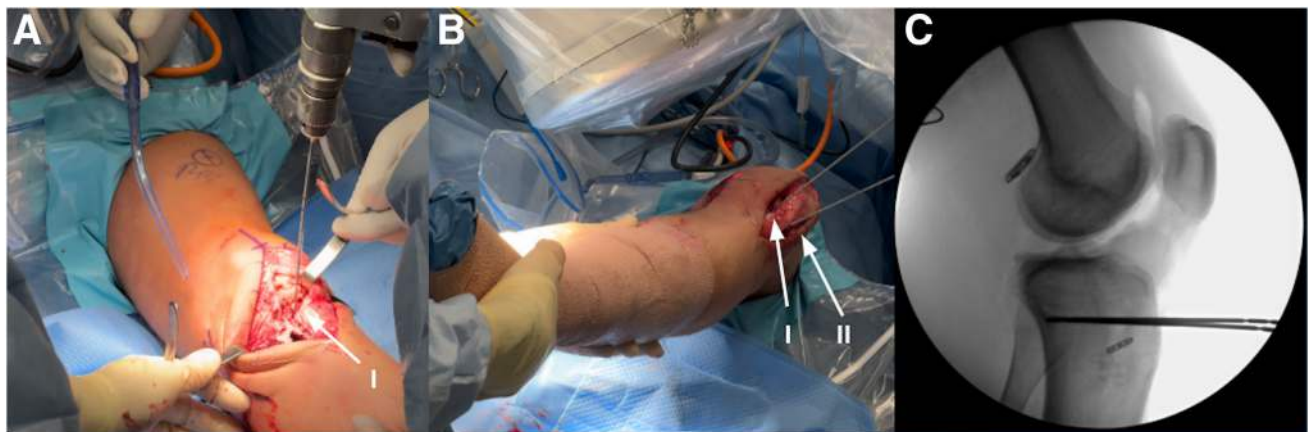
Left knee distal pin placement progression for the slope-reducing anterior closing wedge osteotomy with the patient in a supine position. Two pins (I, II) are placed medial and lateral adjacent to the tibial tubercle and drilled perpendicularly to the tibial shaft and should contact the posterior tibial cortex (A). Intraoperative fluoroscopy (B, C) is used to obtain lateral radiographs to confirm the pin placement without posterior protrusion and the trajectory remains parallel to the tibial shaft.
